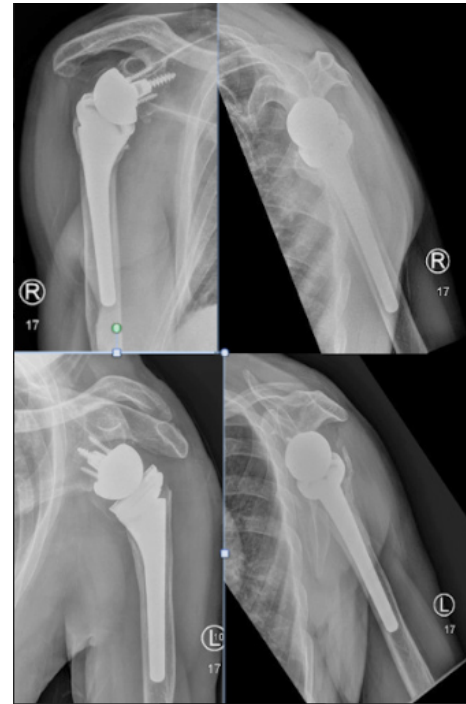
Post-operative AP and Scapular Y radiographs of the right (above) and left shoulders.
